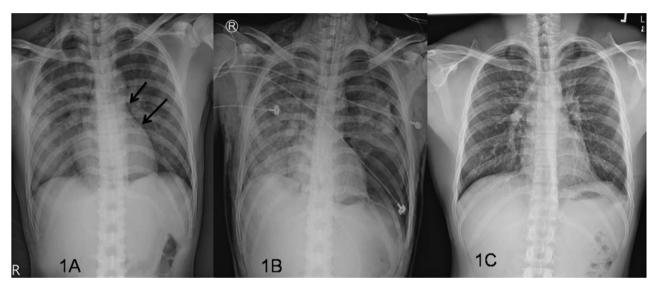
Chest roentgenogram of the patient. Radiolucency line around the heart border is indicated by an arrow on admission day (A). During hospitalization, subsequent pneumothorax occurred in the left lung field (B). Resolution of pneumomediastinum, pneumothorax, and pneumonia after discharge from hospital (C).
